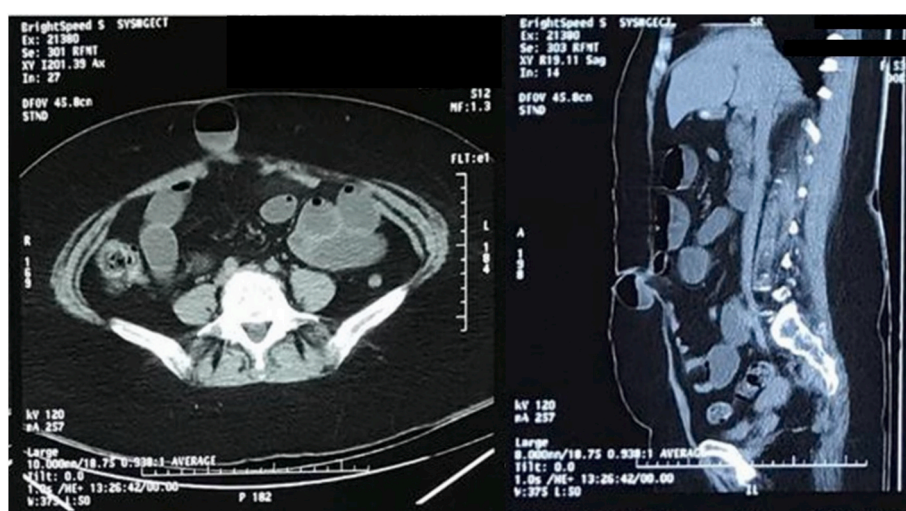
Abdominal CT scan both axial and sagittal plane showed a loop of small bowel with air-fluid level within the abdominal wall in umbilical area.
